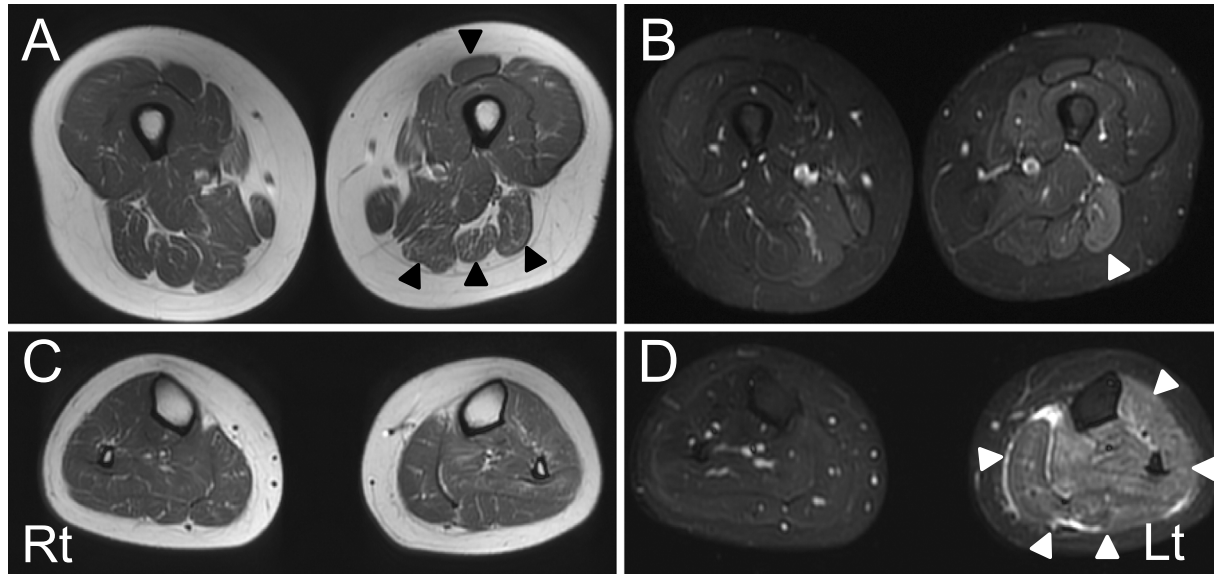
MRI of the lower extremities. (A) T1-weighted image of femoral muscles shows muscle atrophy of the left sartorius, biceps femoris, semimembranosus, and semitendinosus (arrowheads). (B) Fat suppression image of femoral muscles shows hyperintense signals in the left biceps femoris muscle (arrowhead). (C) T1-weighted image of the calf muscles shows no muscle atrophy. (D) Fat suppression image shows diffuse hyperintense signals in both the anterior and posterior compartments of the left lower leg muscles.
